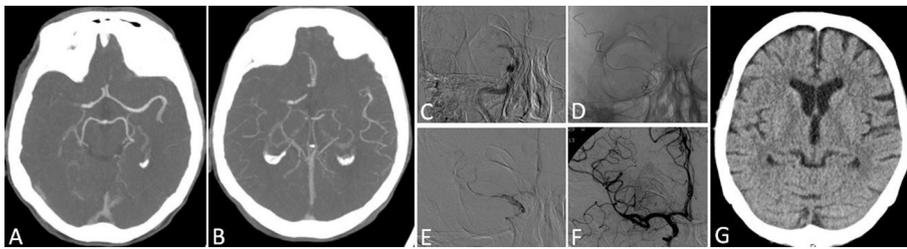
Exemplary axial CTA maximum intensity projection (MIP) demonstrate proximal occlusion of the right-sided M1 segment (A) with good collaterals. Tan Score was 2 (> 50% of affected MCA territory opacified in comparison to non-affected MCA territory) (B). The combination of both angiographic images via guiding-catheter proximal occlusion site (C) and via microcatheter after thrombus passage (D) demonstrates thrombus extension. Angiographic control run with opened stent retriever (Aperio) covering the thrombus (E). TICI 3 final recanalization was achieved (F). Basal ganglia without signs of infarction on postinterventional control NCCT (G).
